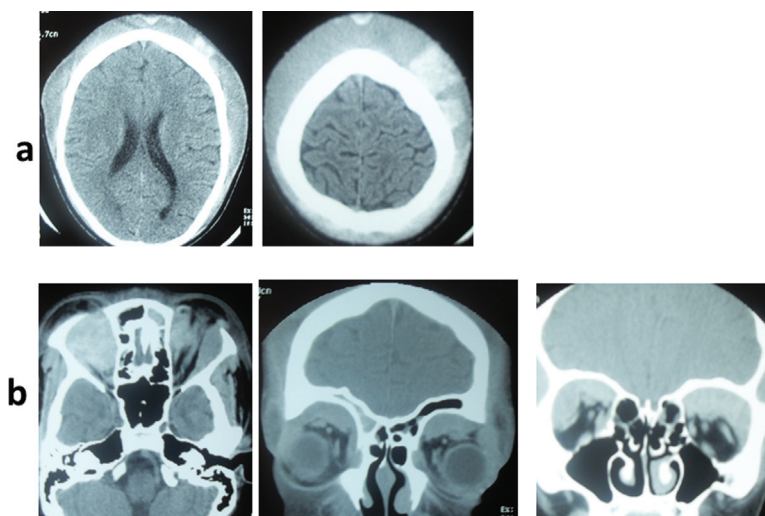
Cranial CT images of the massive SGH and OSPH: (a) axial CT image showing the massive mixed-density subgaleal collection; (b) axial and coronal images showing the intraorbital bleed. The lesions are extraconal and involve the frontal orbital periosteal spaces. There is associated involvement of the right frontal sinus
